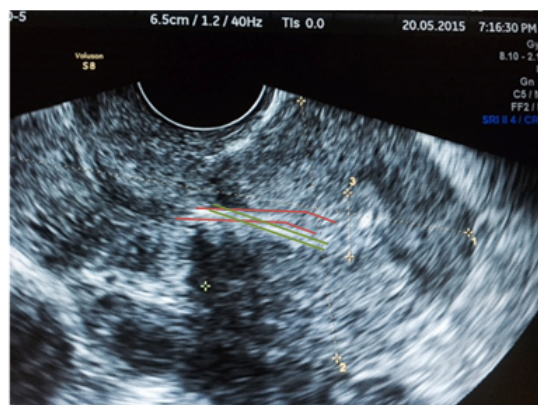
Trans-vaginal ultrasound aspect of the uterus with normal dimensions (1) – longitudinal axis 75 mm (2) – sagittal axis 45 mm but note the distension of the uterine cavity (3) due to the presence of two distinct intrauterine devices inside the endometrial cavity – the red lines mark a Multiload intrauterine device– the green lines mark the lenorgestrel-releasing intrauterine system
